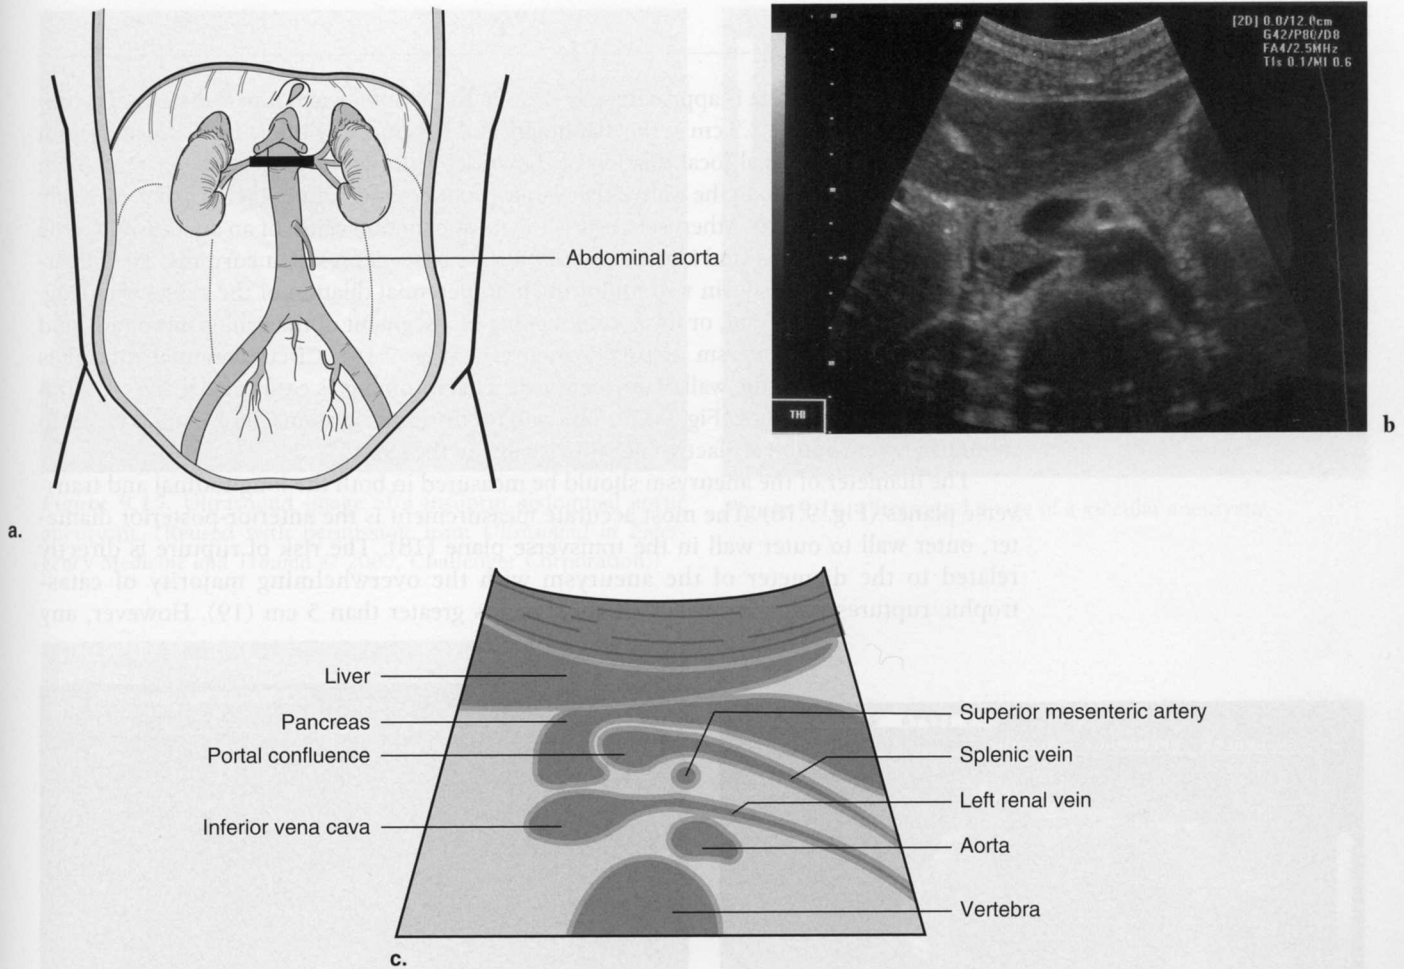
The aorta at the level of the superior mesenteric artery (SMA) in transverse orientation. The transducer is placed approximately 2 cm inferior to the take-off of the celiac trunk in a transverse orientation (A). Ultrasound image at the level of the superior mesenteric artery (B). The portal confluence, superior mesenteric artery, aorta, and inferior vena cava are all visible at this level (C).
